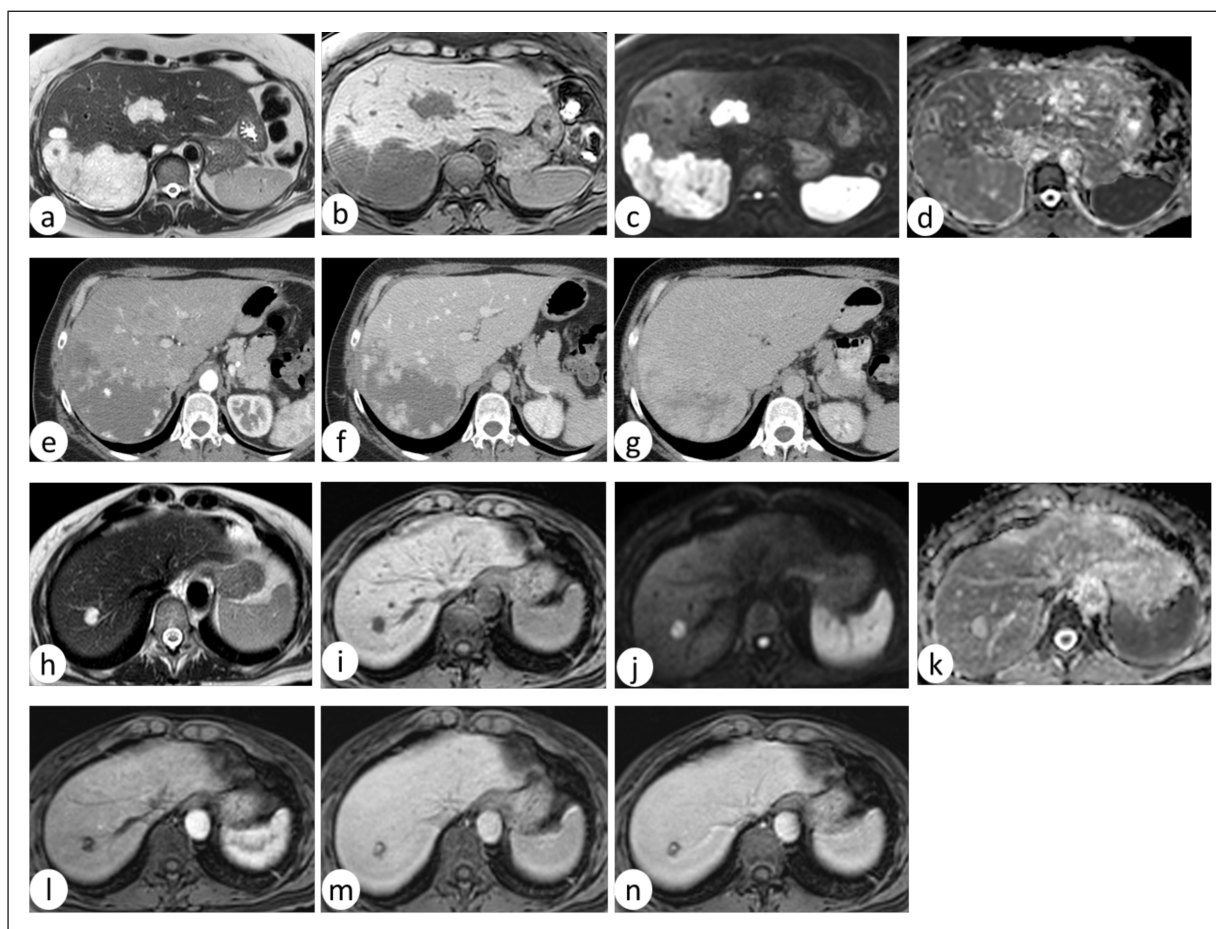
Hepatic Hemangioma (HH). a-g, Giant cavernous HH. (h-n) small, typical HH. (a,h) T2w images; (b,i) 3D GRE, fat-suppressed, T1w images; (c,j) DWI $b=800$ s/mm²; (d,k) ADC map (mm²/s). e-g, contrast-enhanced CT (late arterial, portal, venous phase). l-n, contrast-enhanced MRI with 3D GRE, fat-suppressed, T1w images (late arterial, portal, venous phase). Lesions show the typical marked T2 hyperintensity and hypointensity on T1w images. The consensual assessment of DWI and ADC maps allow to avoid the T2 shine-through effect visible as hyperintensity on b800. The contrast studies show peripheral nodular enhancement, which is comparable to the vascular compartment (*parallels blood pool enhancement*).
